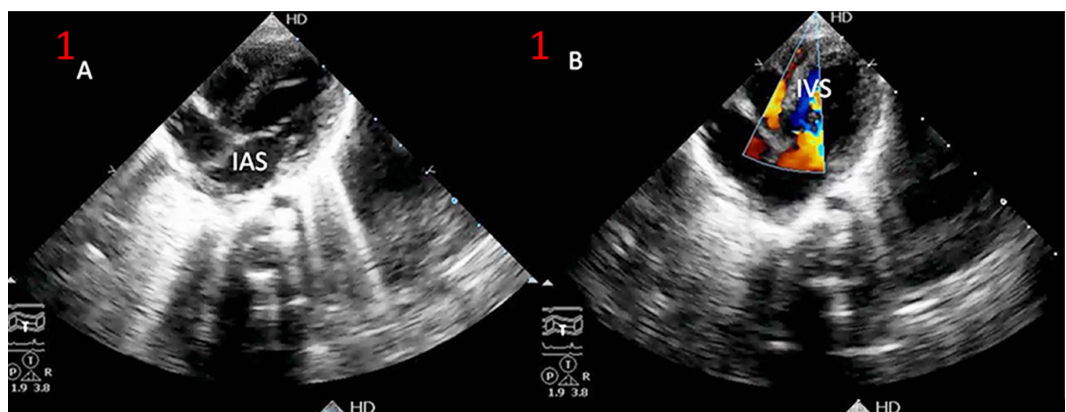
(A and B) Subcostal echocardiography revealing intact inter-atrial septum and inter-ventricular septum.
